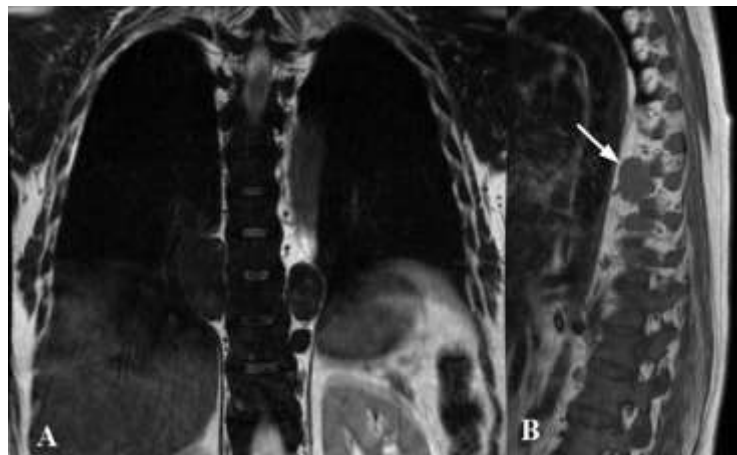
Paravertebral foci of extramedullary hematopoiesis in a 48 female patient suffering from thalassemia. MRI - coronal T2w (A) and sagittal T1w (B) images - shows oval homogeneous and well-margined lesions corresponding to ectopic hematopoietic tissue in the right paravertebral side at D8-D9 level, and in the left paravertebral side on D9 level (white arrow in B).
